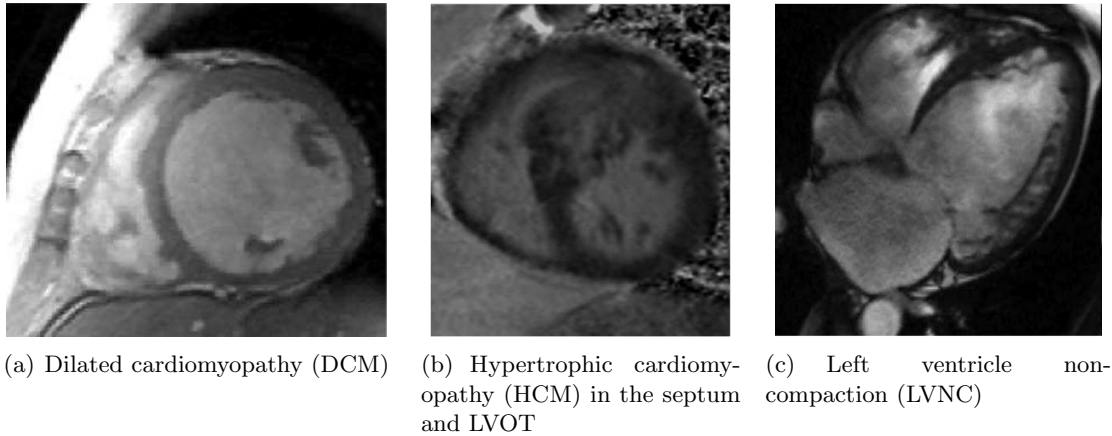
Selected cardiomyopathies in MRI.
